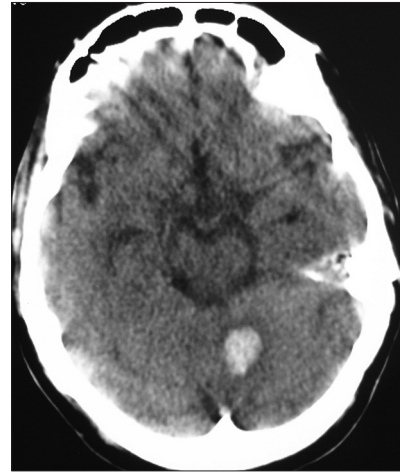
Postoperative fourth day CT scan revealed a left cerebellar hematoma
